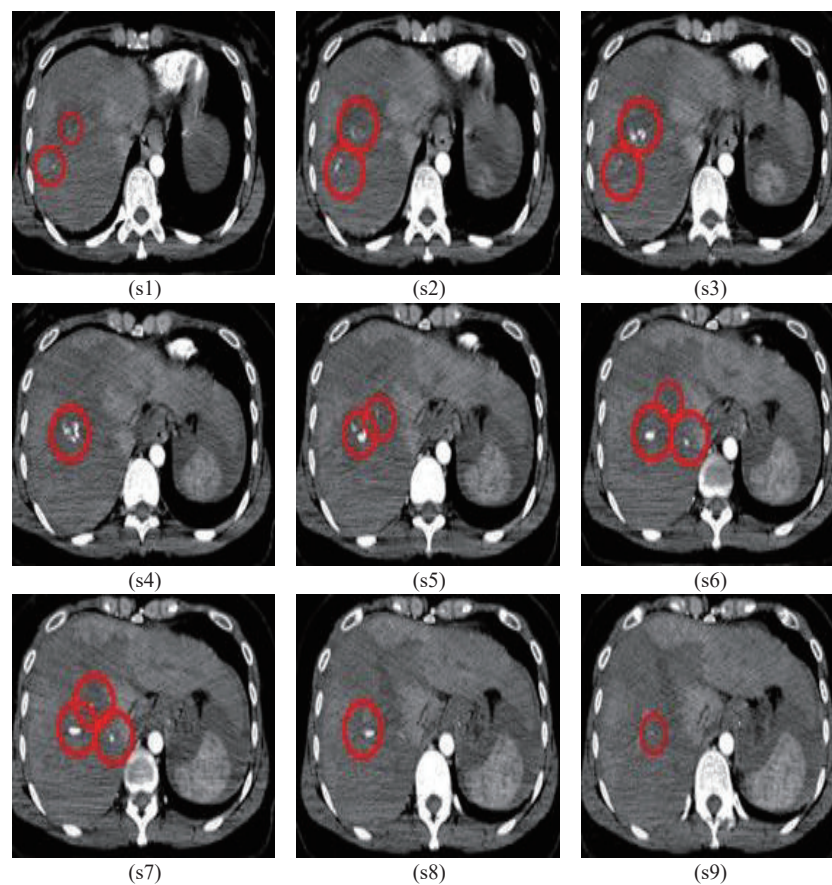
Sequential CT showing extravasation (marked with circles) within the liver, where s1, ..., s9 indicate slice #1, ..., slice #9.
